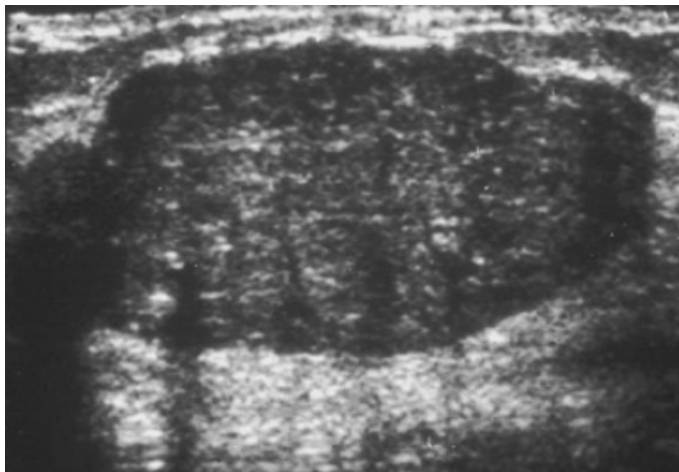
Ultrasound appearances of a fibroadenoma
